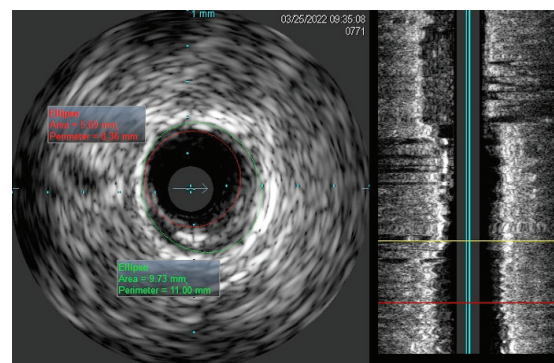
Intravascular ultrasound of proximal LAD – protentional landing zone
